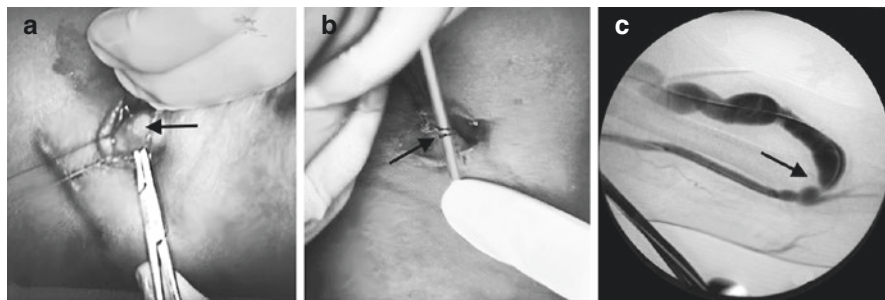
Extraluminal precision banding of CAS. (a) Exposure of juxta-anastomotic zone of AVF, (b) Extraluminal ligation over vascular dilator, (c) Radiographic appearance of final results
